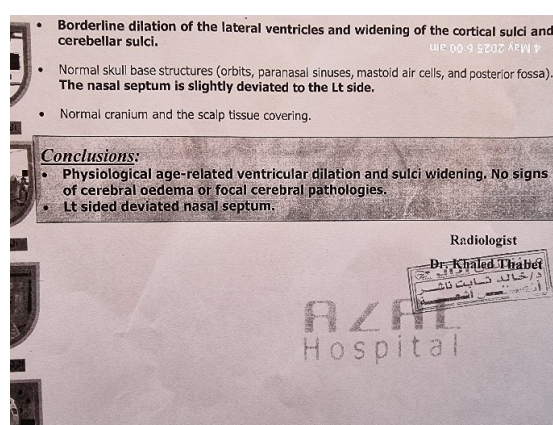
Brain CT scan showed no cerebral pathologies
